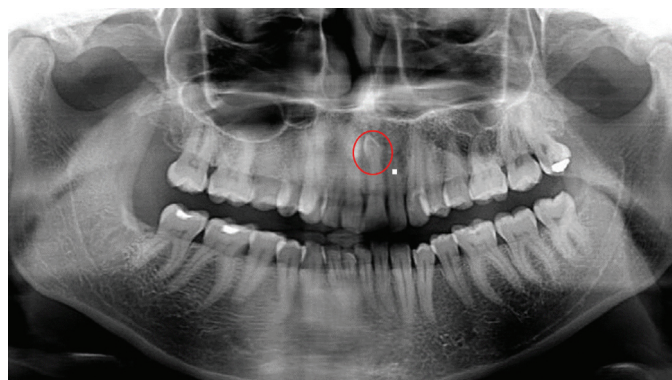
Dental panoramic radiograph of the patient, demonstrating the presence of an unerupted early-forming (conical) supernumerary tooth associated with the root of the UL1.
